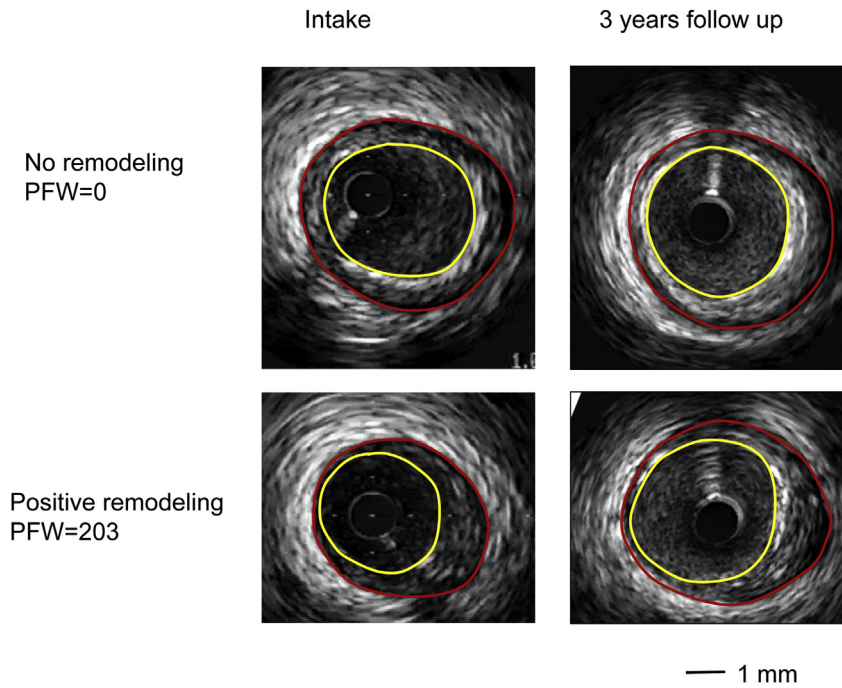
Representative intravascular ultrasound cross section of 2 different segments: Upper panels: PFW = 0° at baseline and lower panels PFW = 203° at baseline (yellow = lumen; red = boundary at lamina elastica externa = vessel area). At follow up a different response is observed for the segment with PFW<180°: no remodeling (right, upper panel), while for the segment with PFW>180° positive remodeling was observed (right, lower panel).
